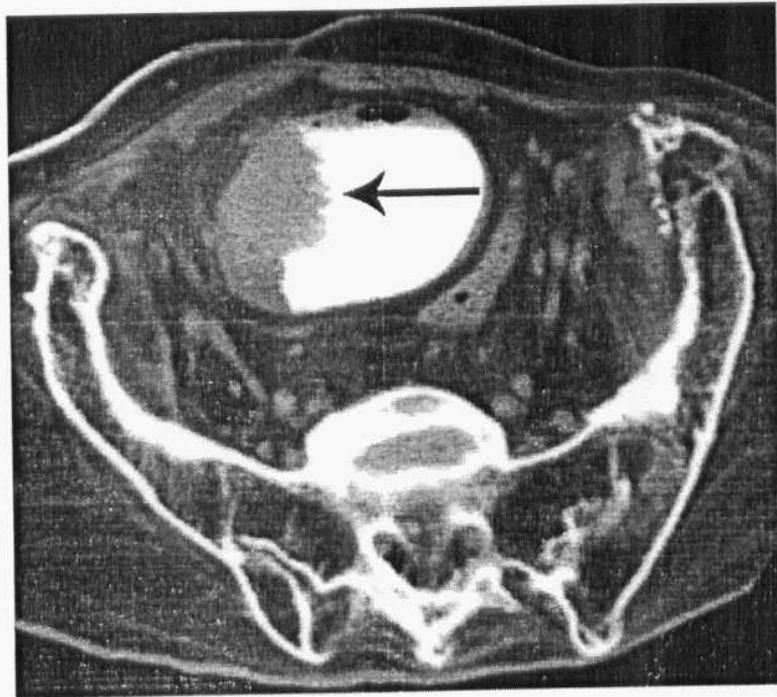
Axial enhanced CT cystogram shows a large mass on the right lateral wall.
